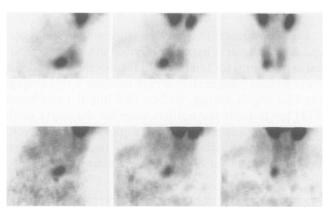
Anterior (*right*), oblique (*middle*), and lateral (*left*) views from a computer-generated three-dimensional reprojection of early (above) and delayed (below) MIBI single photon emission computed tomography. The parathyroid tumor is localized inferiorly and dorsally to the right lobe of the thyroid gland.
